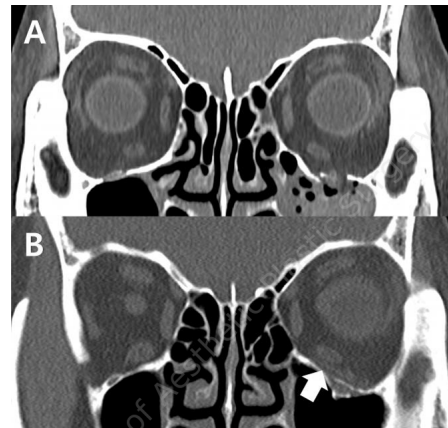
(A) Preoperative computed tomography scan showing a blowout fracture of the left orbital floor. (B) Postoperative scan obtained 6 months after the initial repair, demonstrating stable reconstruction of the orbital floor with an implant.
